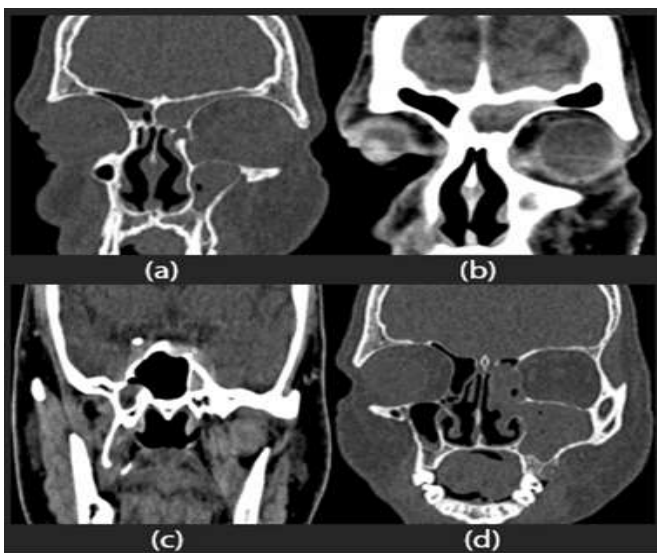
(a), (b), (c) - Soft tissue density with hyperdense areas observed in the bilateral maxillary, ethmoid, frontal, and sphenoid sinuses on CT-PNS; (d) Mild expansion of left maxillary sinus with occlusion of osteomeatal complex and no evident bony erosion or expansion into the intracranial and orbital spaces.
